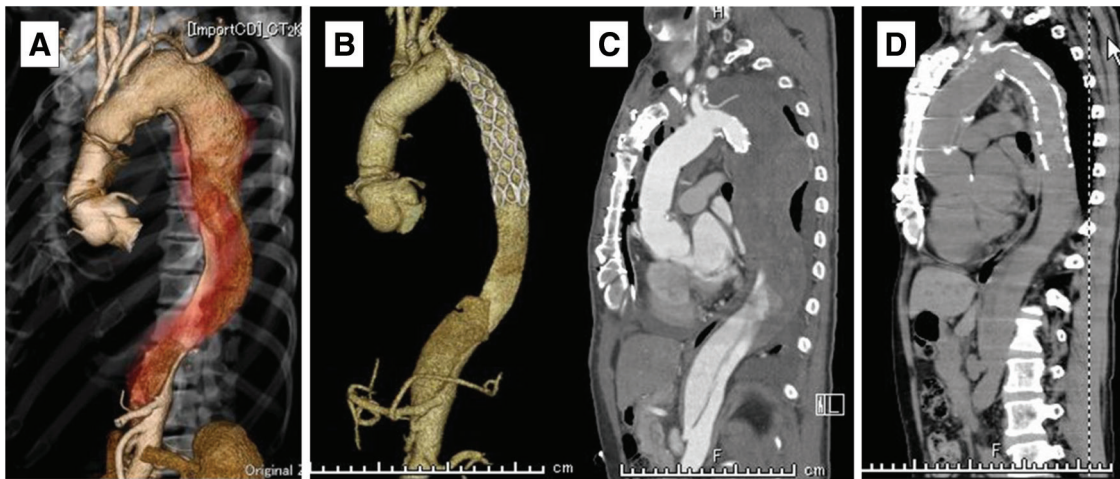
Complete remodeling of the thoracic aorta after the FET operation. (A) Preoperative 3-dimensional computed tomography of a patient after hemiarch replacement for acute type A aortic dissection performed elsewhere. (B) Postoperative 3-dimensional computed tomography after the FET operation. (C) Multiplanar reconstruction of the postoperative computed tomography showing the dilated false lumen. (D) Multiplanar reconstruction of the computed tomography 2 years postoperatively showing complete remodeling of the thoracic aorta. FET: frozen elephant trunk
